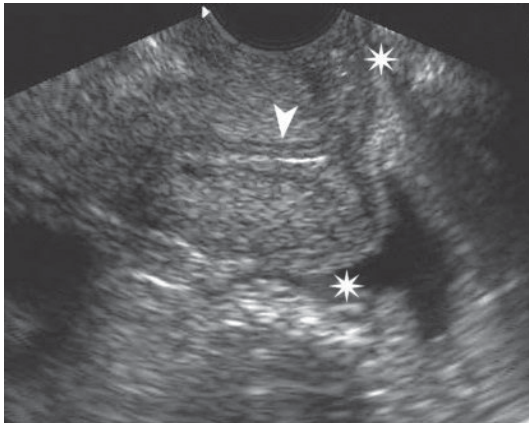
Transvaginal ultrasonography. Longitudinal scan. Uterine cervix. The *arrowhead* indicates the hyperechoic cervical canal. The *asterisks* are positioned at the level of the vaginal fornices
